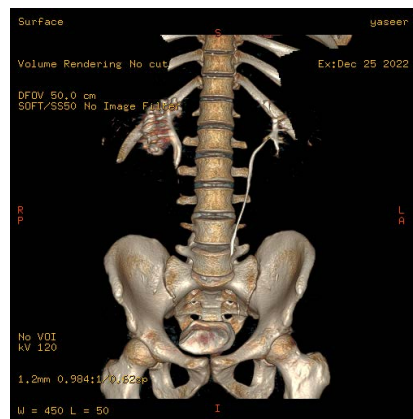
Post-operative CT with IV contrast of Case 3 showed right the proximal ureter running in its normal course lateral to the IVC.
